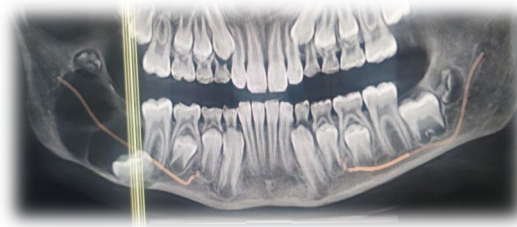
Preoperative orthopantomography showing a well-defined multilocular image. The lesion involves the right second molar, which has an open root apex, indicating it is still in an immature state.
